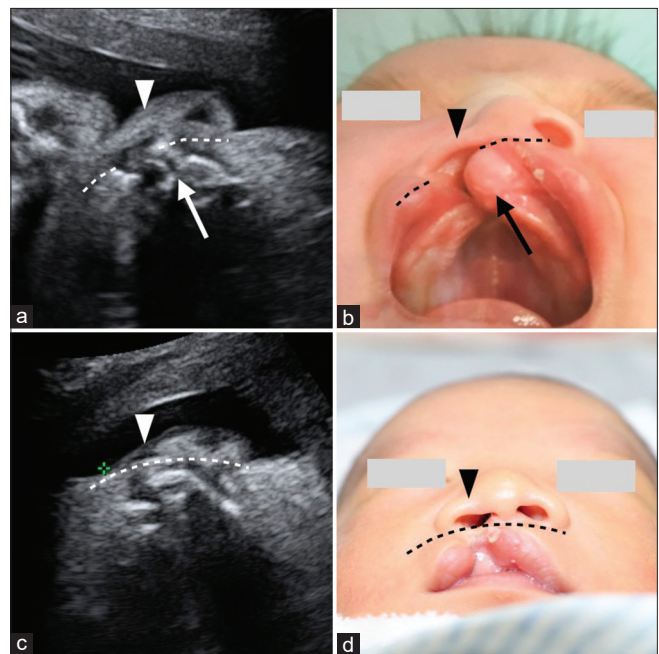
Two-dimensional ultrasound images of lip and upper alveolus on the oblique axial view and corresponding postnatal photographs for complete (a and b) and incomplete (c and d) orofacial clefts. In the complete type (a and b), the affected-side nostril (arrowhead) is collapsed and the noncleft side's alveolus protrudes into the cleft side's nasal cavity (arrow), resulting in the broken nostril floor. In the incomplete type (c and d), the affected-side nostril is smaller (arrowhead) with intact nostril floor (dashed line)
